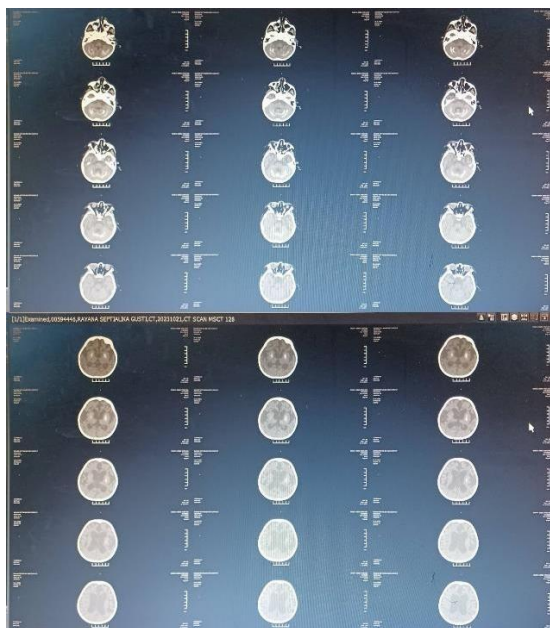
CT imaging of brain.
